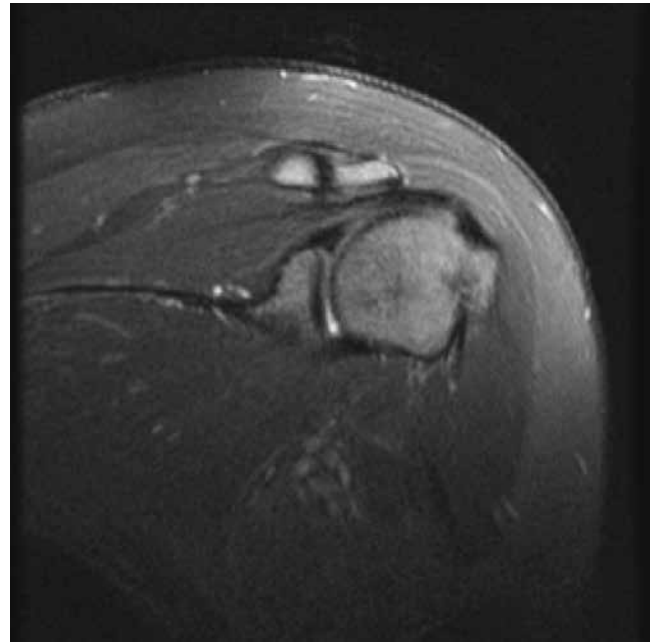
Magnetic Resonance Imaging showing an anterior labral tear, superior migration of the humeral head, and a Hill-Sachs lesion.
